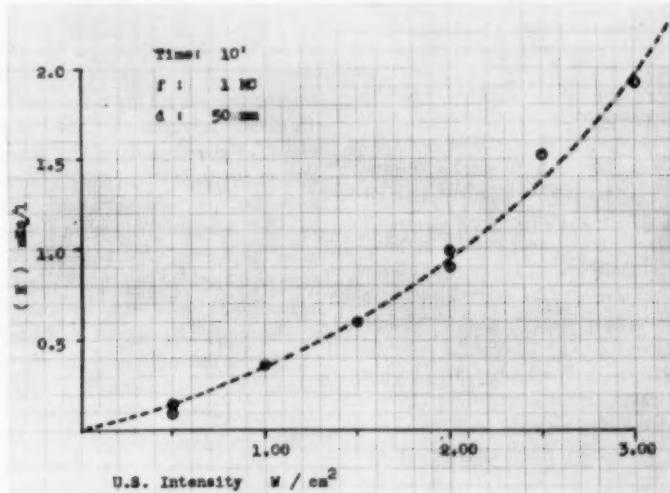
Relationship of potassium diffusion to intensity of ultrasound.
